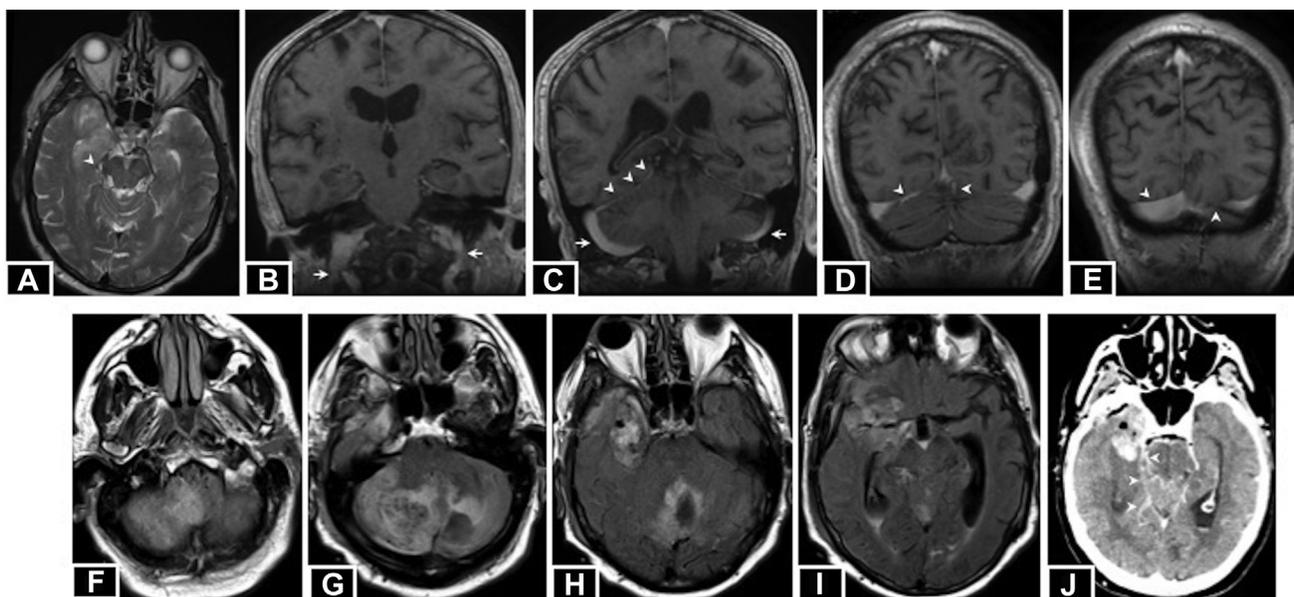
Magnetic resonance imaging (MRI) and computed tomography studies of temporal lobe glioma with remote cerebellar and brainstem infarct after resection. (A–E) Preoperative MRI. The bridging vein of the inferior temporal lobe to the tentorium is seen on the axial T2 FLAIR sequence in (A) (*arrowhead*). A difference in caliber of the jugular bulb is seen in the coronal T1 postcontrast sequence in (B); the right is narrowed distally with dilation proximally, whereas the left is narrowed proximally (*arrows*). Dilation of the right sigmoid sinus compared with the left is seen on the coronal T1 postcontrast sequence in (C) (*arrows*). In the same slice, tentorial vessels are seen in the plane of the tentorium (*arrowheads*). More posteriorly, the cerebellar bridging veins, right more lateral than left, are seen draining into the tentorium (*arrowheads*) in the coronal T1
